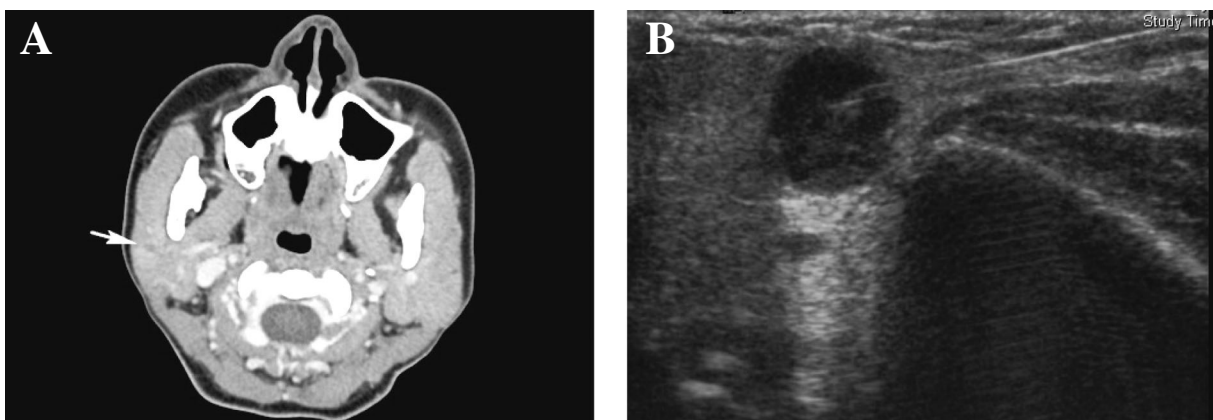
Abbreviation: UGFNAB: ultrasonography-guided fine needle aspiration.
